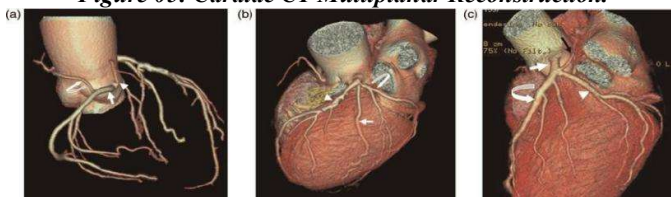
Volume rendered (VR) Image of Cardiac CT.
